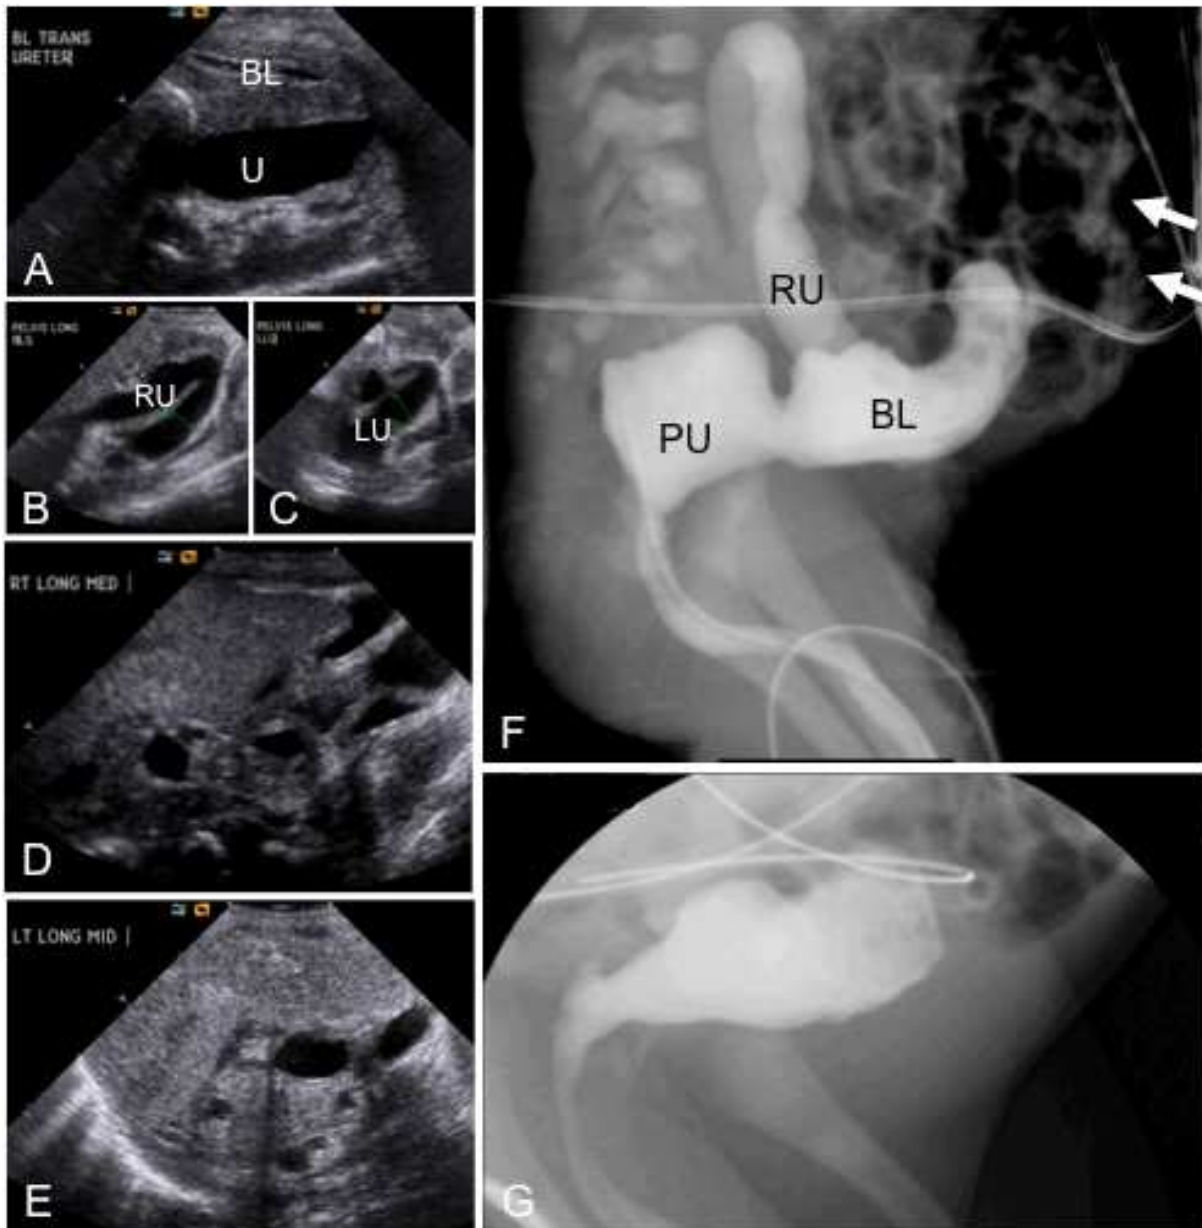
Radiological findings associated with prune belly syndrome in a 2 day old male. A - E. Ultrasound of urinary bladder (A), right (B) and left (C) ureters, right (D) and left (E) kidneys. The bladder (BL) is decompressed but bladder wall thickness is normal. Tortuous dilated ureters (U, RU, LU) are observed bilaterally in the lower abdomen. The kidneys are dysplastic and amorphous in appearance, with cysts of varying sizes. There is no corticomedullary differentiation in either kidney. F. VCUG. The protuberant abdomen resulting from lack of abdominal wall musculature is evident from the position of bowel loops (arrows) on this lateral view. This patient has an unusual configuration of the bladder, bladder base and posterior urethra. There is absence of the normal prostate and a very distended posterior urethra (PU) connecting to a dysplastic-appearing bladder (BL). No evidence of true PUV was found on this or any subsequent investigations. Reflux is observed into the distended right ureter (RU) but not the left. G. VCUG from another patient 10 days postnatally shows a more typical trabeculated bladder with the characteristic tubular shape of the bladder base in prune belly syndrome.
